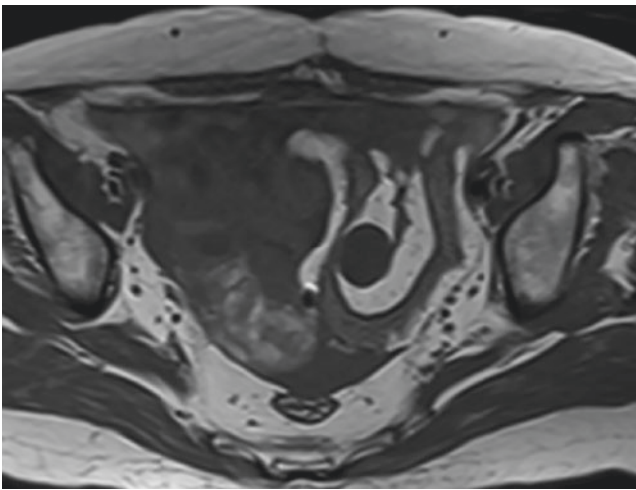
Axial T1-weighted image showed heterogeneous signal intensity caused by intratumoral hemorrhage
